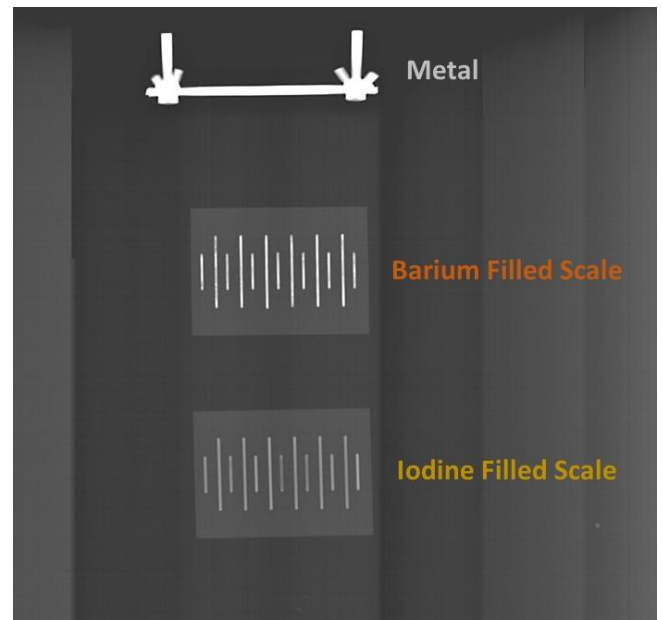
Radiographic image of the scales along with a metal object used as the control.
